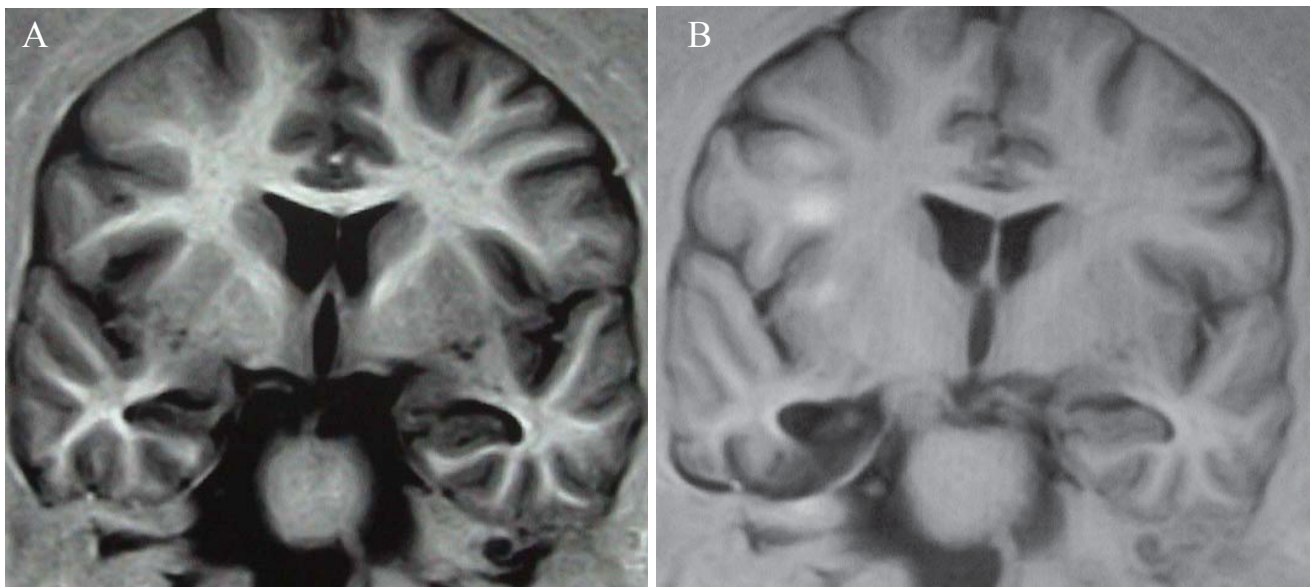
A: Preoperative MRI, TIWI of patient 2 showing right hippocampal sclerosis, B: postoperative image showing the extent of surgical resection in SAH.
